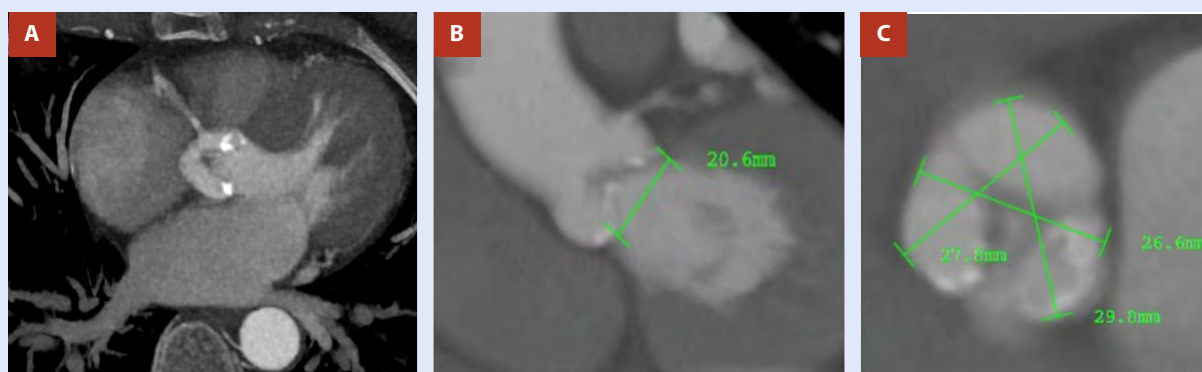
A. Preoperative CT imaging revealing severe aortic annular calcification. B. Aortic annular dimensions measured by CT. C. Intersinus dimensions assessed by CT.
